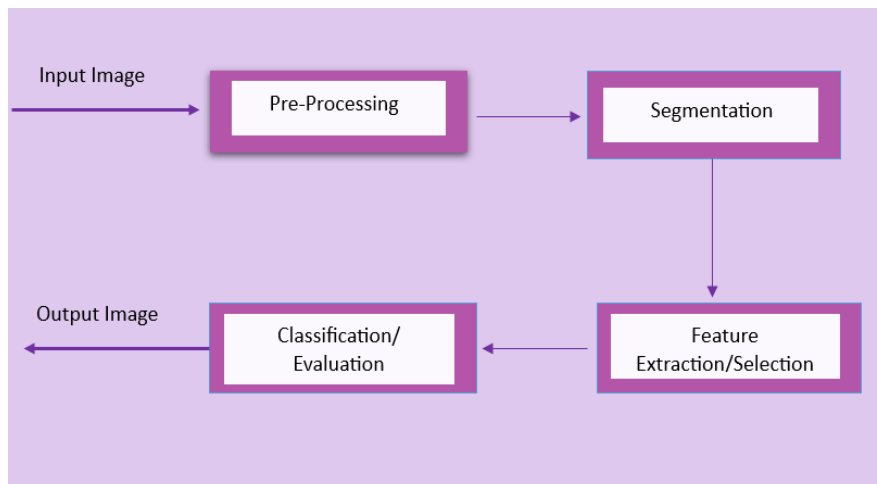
Stages of breast cancer detection and Growth Prediction on Ultrasound images
